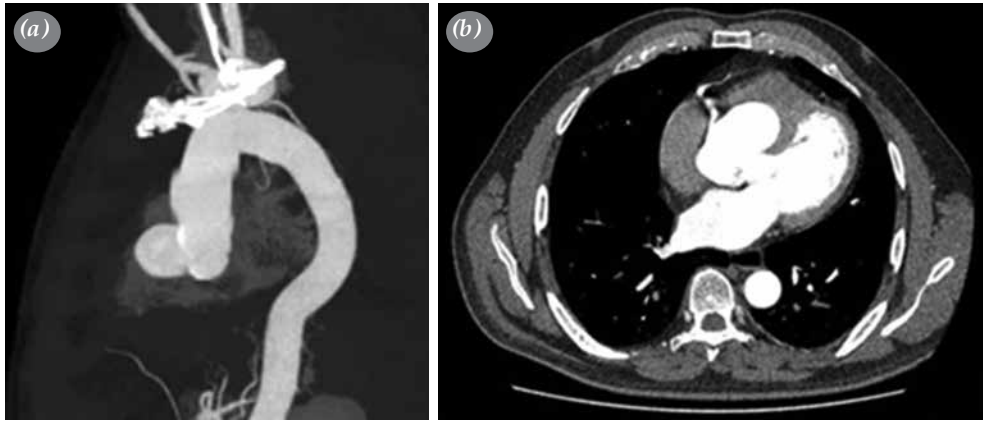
(a, b) Preoperative image of computed tomographic three-dimensional angiography.
